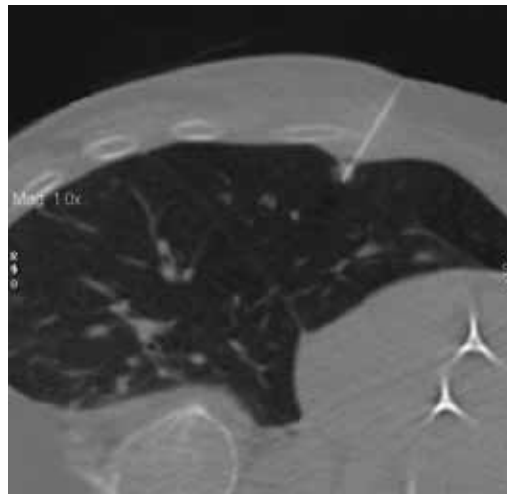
CT scan showing radiofrequency ablation needle in cancer tissue.
